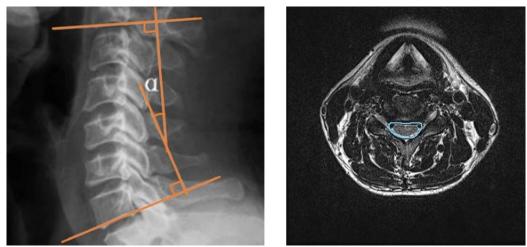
Cobb angle of cervical lordotic curve, Figure 3 Central canal area in axial view of cervical spine MRI
